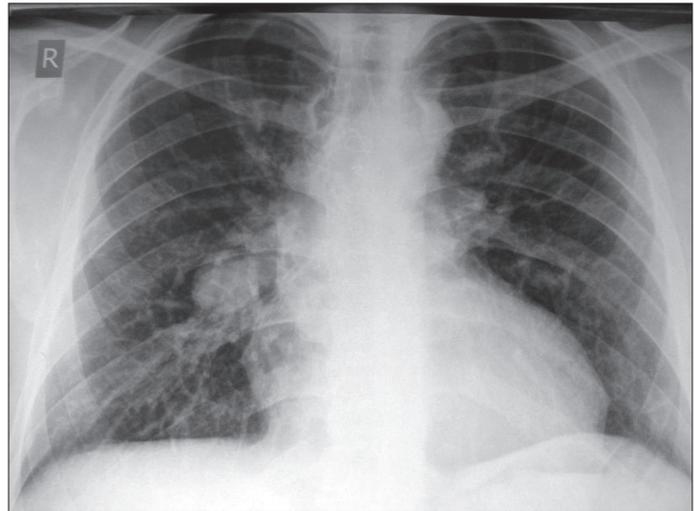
Chest X-ray of our case showing abnormal shadowing in the right pulmonary hilus
